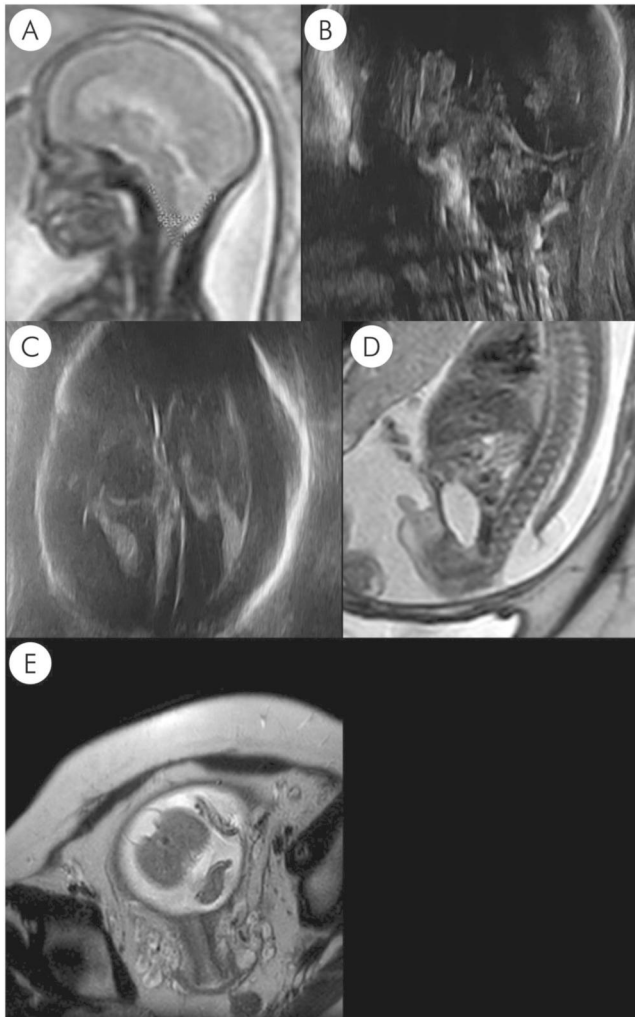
(A–E) Prenatal US and MRI images of case 12 at 22.9 weeks gestation: A + B Sagittal T2-weighted MRI and US of the brain and upper spinal cord show a small posterior fossa with downward herniation of the inferior vermis and cerebellar tonsils below the foramen magnum with effacement of the fourth ventricle and cisterna magna. CSA measures 56°. (C) Occipital colpocephaly and mild ventriculomegaly (12 mm). (D + E) T2-weighted sagittal (D) and axial (E) fetal MRI show the spinal defect with herniation of the neural structures.
